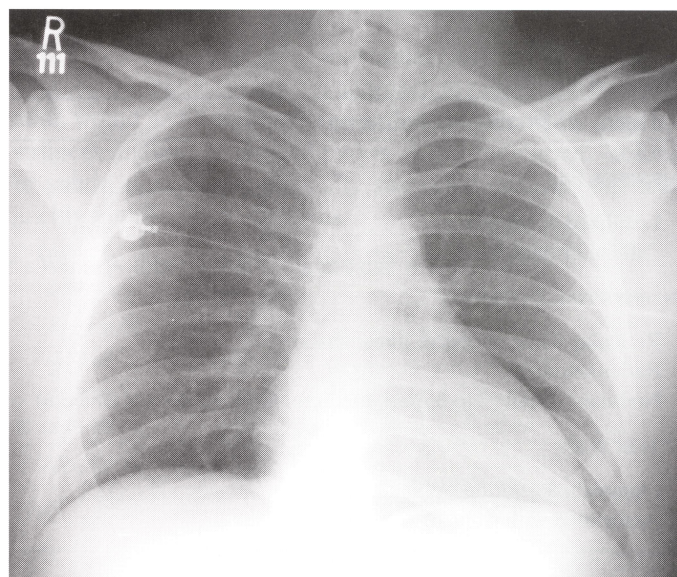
A properly performed supine AP portable chest radiograph.
